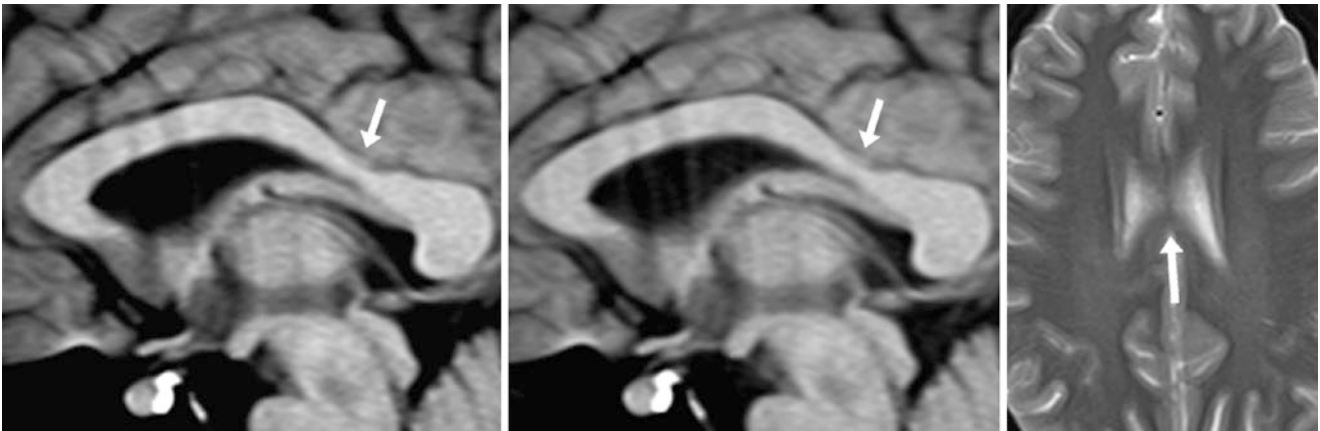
A 27-year-old patient; an otherwise negative MRI obtained for headaches showed a normal, moderately thinned callosal isthmus (arrows) on midline sagittal T1WIs (*left and middle*). An axial T2WI (*right*) did not show the thinning clearly
